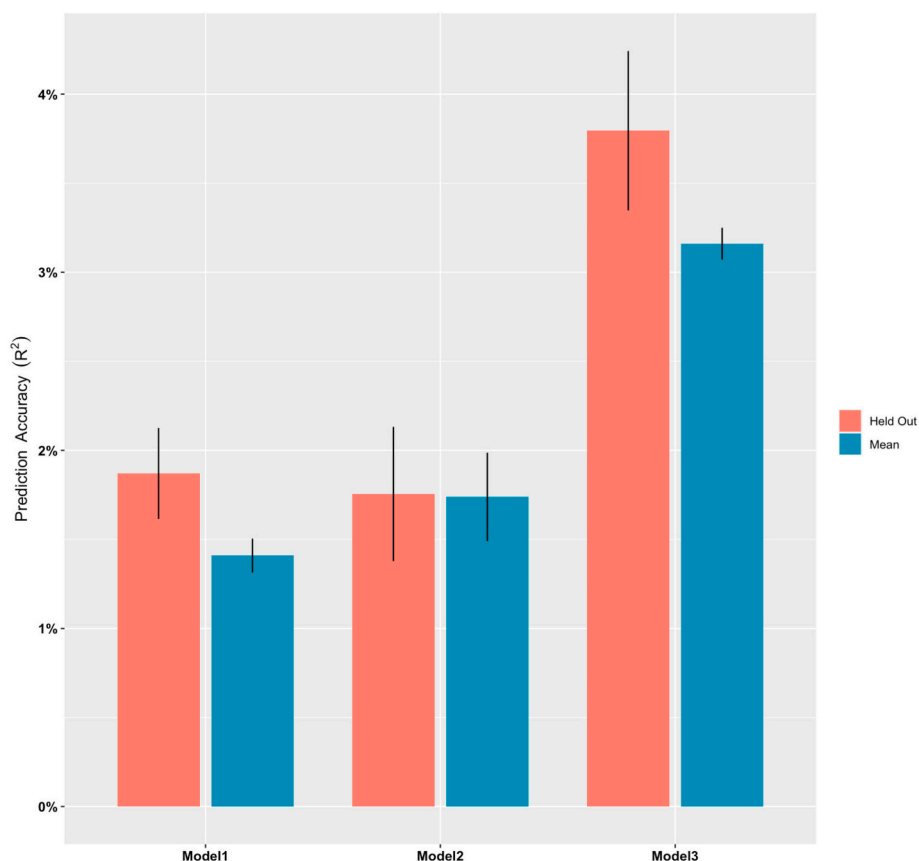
Prediction Accuracy (R^2) for elastic net regression models to predict anxiety problems. In Model 1, regional sMRI variables (i.e., the CT and CSA of each cortical region, the GMV of each subcortical region and brain stem) were predictors. In Model 2, demographic variables (i.e., age, sex, total family income, and education level) were only used as predictors. In Model 3, both sMRI variables and demographic variables were used as predictors. “Mean” indicate the mean R^2 of all models built in the training phase. “Held Out” indicates the all R^2 of all models from the training phase being tested on the held-out test set. Error bars stand for standard error of mean. CSA, cortical surface area; CT, cortical thickness; GMV, gray matter volume.
